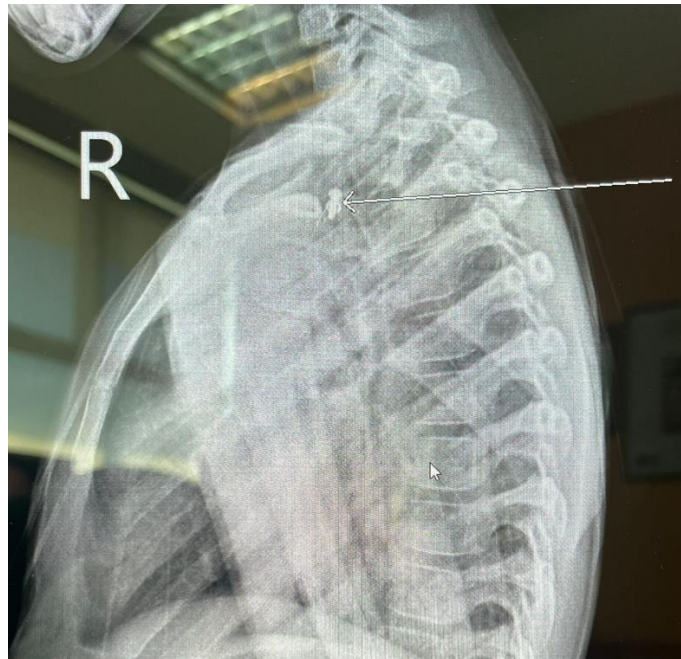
Lateral view of neck xray showed foreign body (white arrow) at the level of T2 vertebrae.
